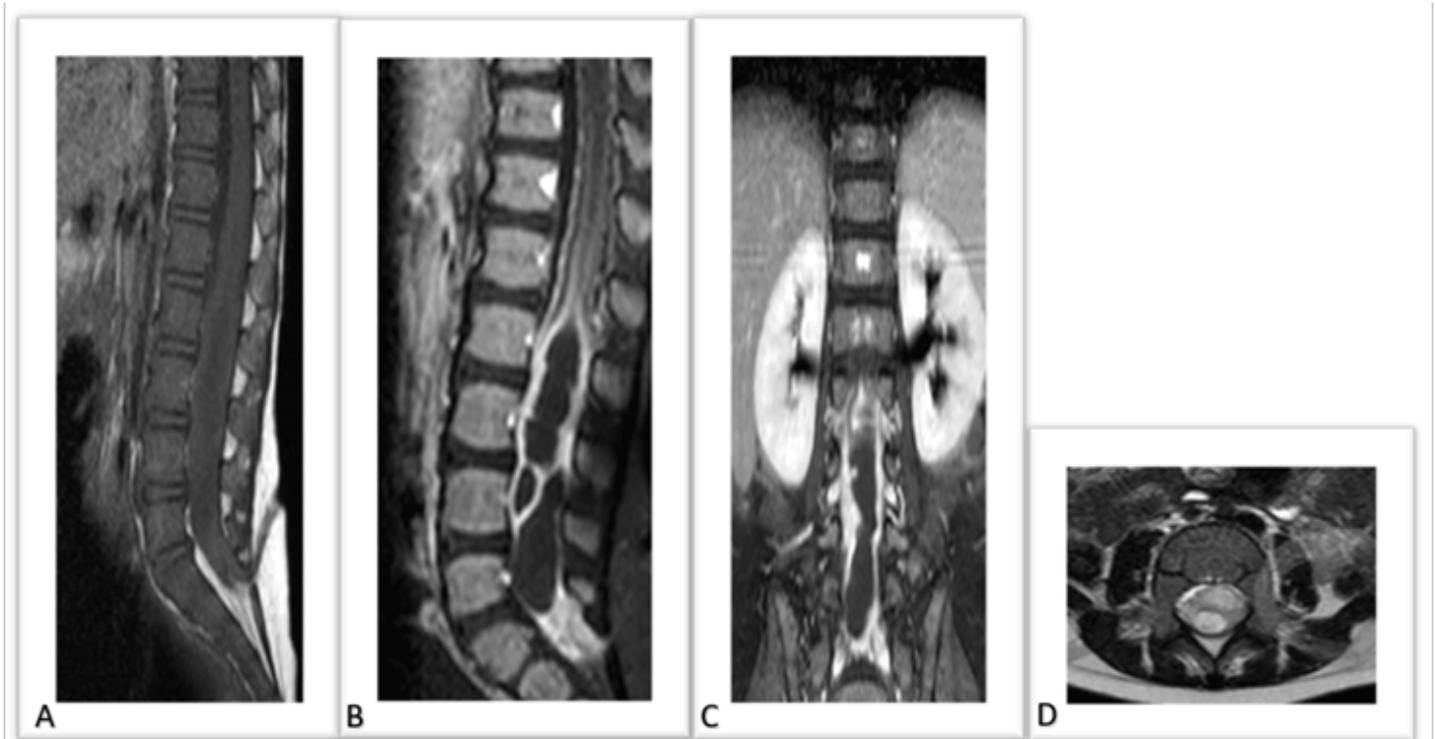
A) sagittal T1 MRI; B) sagittal T1 MRI with contrast; C) coronal T1 MRI with contrast; D) axial T1 MRI with contrast.
